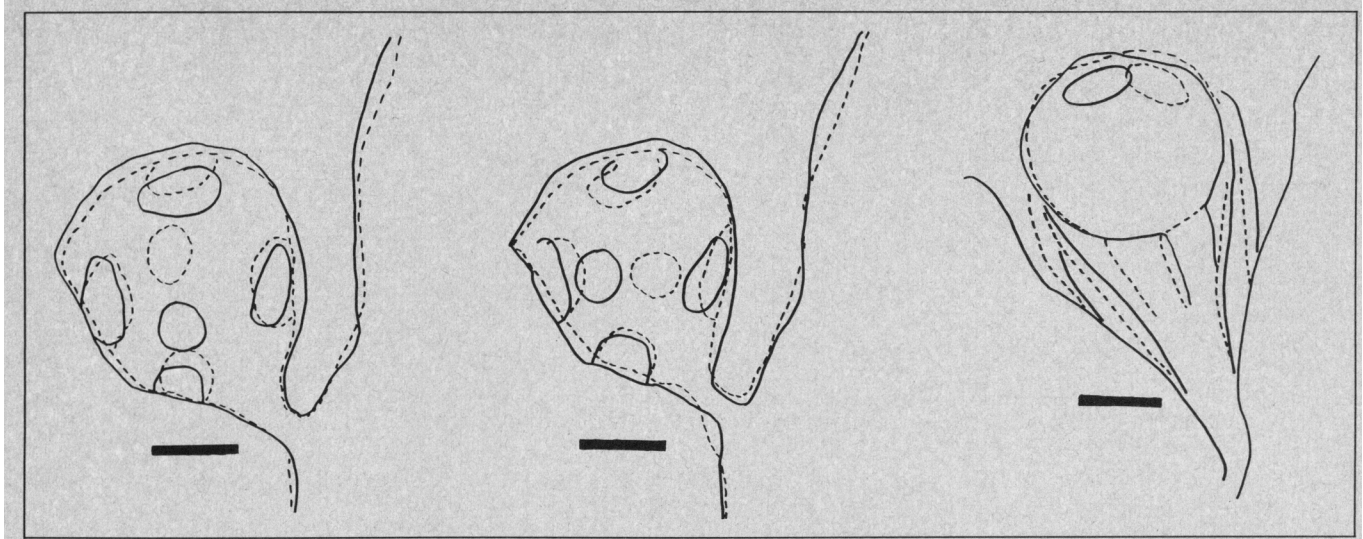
Hand-drawn copies of superimposed computed tomographic scans, made in opposite gaze positions. Left, Scans perpendicular to muscle cone, up gaze (continuous line), and down gaze (dashed line). Center, Scans perpendicular to muscle cone, lateral gaze (continuous line), and medial gaze (dashed line). Right, Horizontal scans, lateral gaze (continuous line), and medial gaze (dashed line) (subject 1, right eye).
